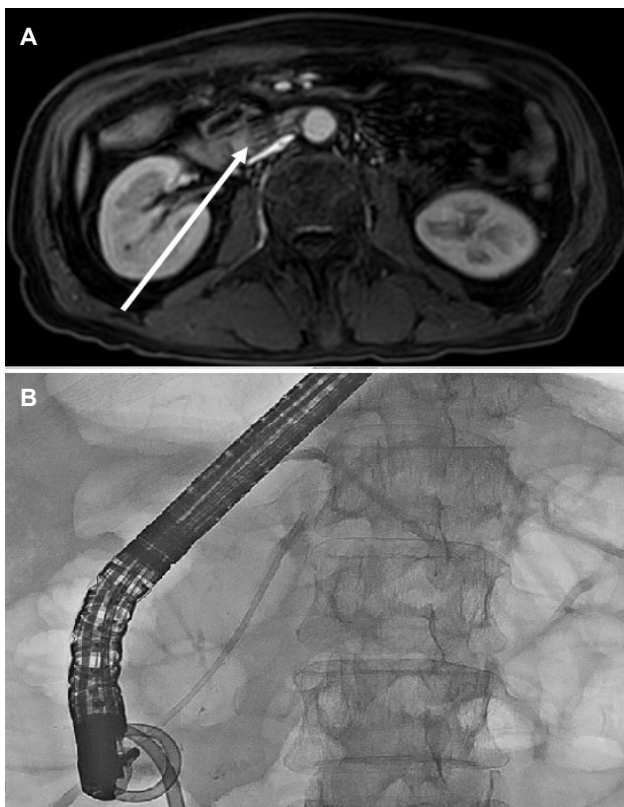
Magnetic resonance imaging and endoscopic retrograde cholangiopancreatography (ERCP) performed to determine the etiology of the elevated serum amylase and lipase and treat pancreatitis (A) increased signal intensity in the T1-weighted image at the head of the pancreas (arrow). (B) ERCP with plastic stenting in the pancreatic duct was performed.
